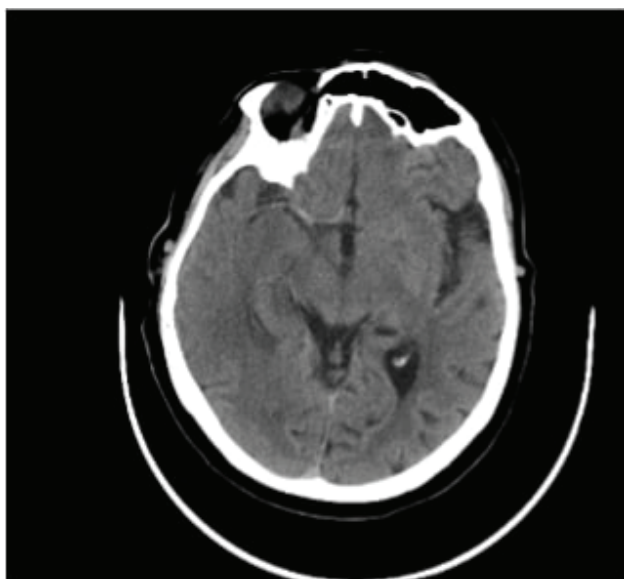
The brain CT shows a hyperdense right middle cerebral artery in the setting of an acute ischemic stroke.
